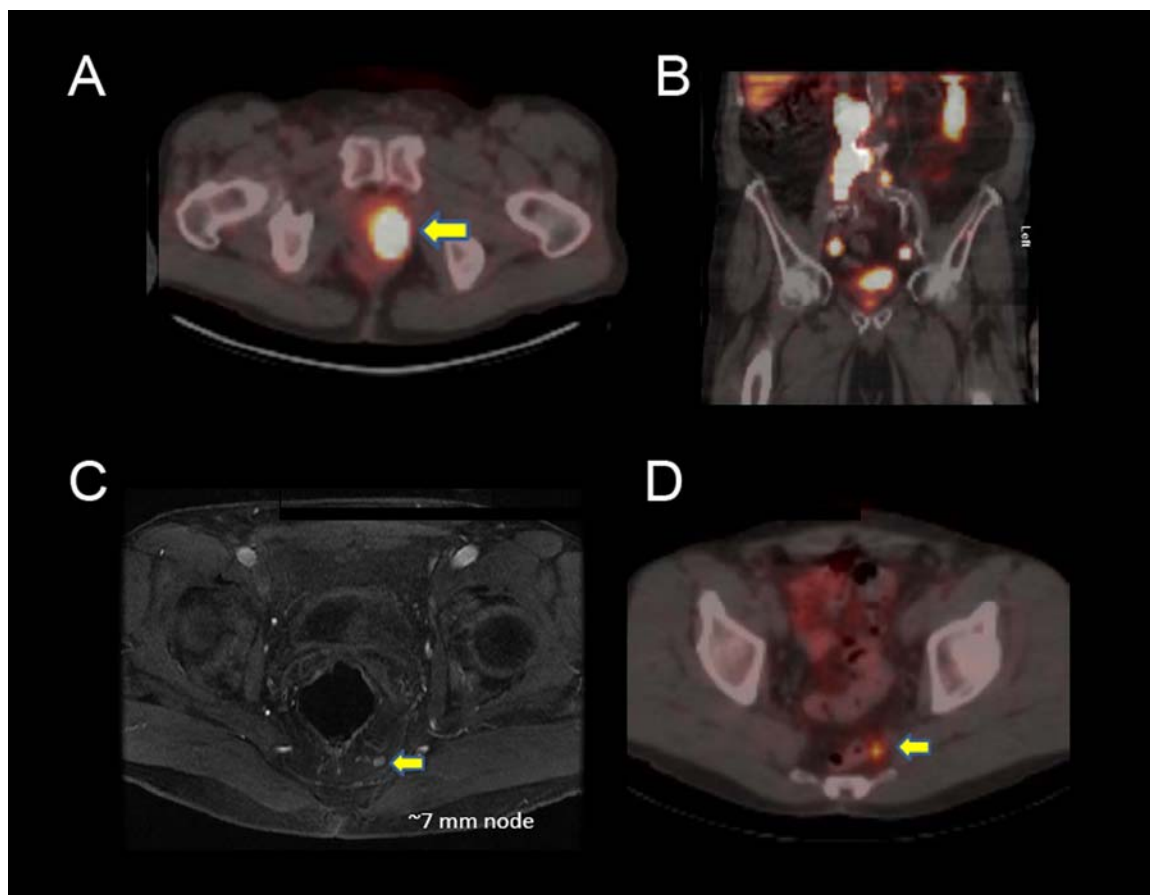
Targeting prostate cancer with the small molecule MIP1404 radiolabeled with Tc-99m. MIP1404 binds to the glutamate carboxy peptidase domain of PSMA and is subsequently internalized into prostate cancer cells.
